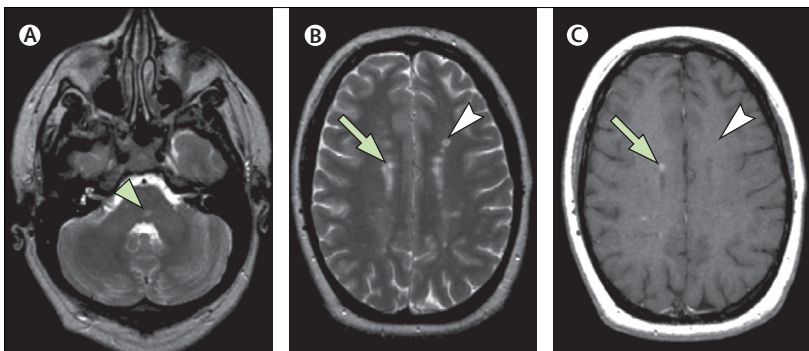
MRI scan of a patient with clinically isolated syndrome
